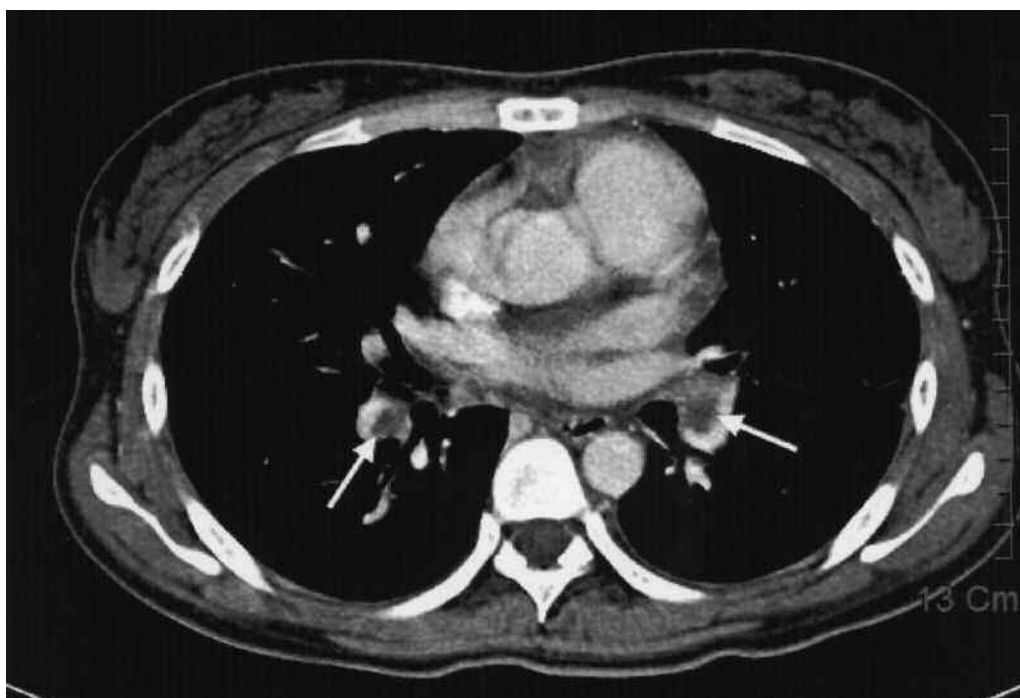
Contrast medium-enhanced chest computed tomography disclosed filling defects within bilateral inferior pulmonary arteries (arrows).
